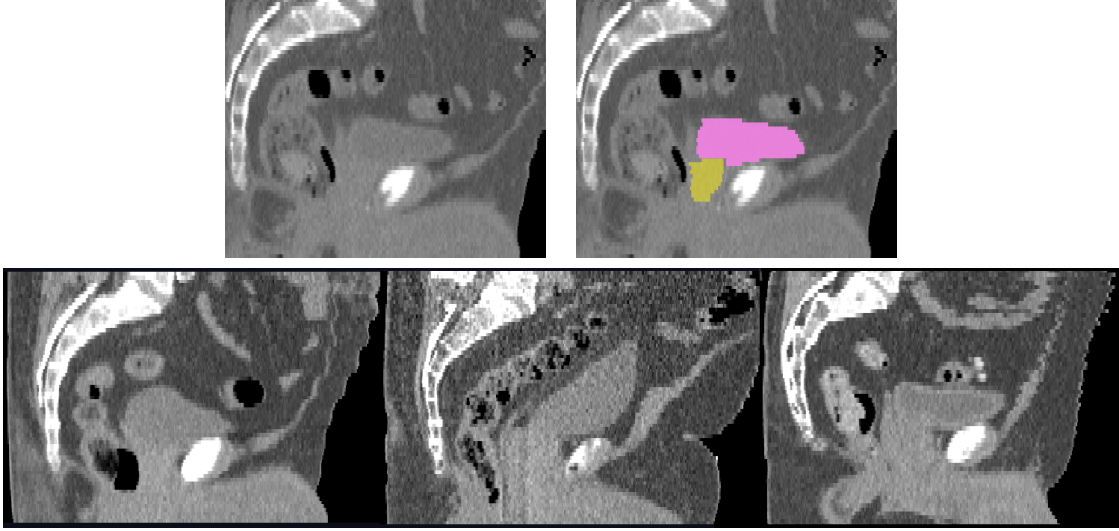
Sagittal male pelvis slices in CT. Top: Original greyscale image on the left, with bladder (pink) and prostate (gold) highlighted on the right. Bottom: Across images, note that the bladder is surrounded by mostly lower intensity bowel and fat, with much brighter tissue from the pubic bones and prostate inferior to (below) it. The prostate has a similarly consistent object-relative appearance. These observations motivate an object-relative regional appearance model.
